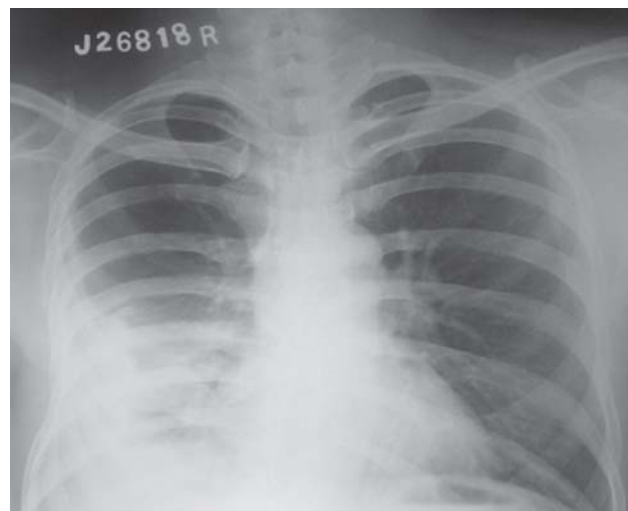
Chest radiograph (postero-anterior view) shows loculated pleural effusion in the right lower zone.
